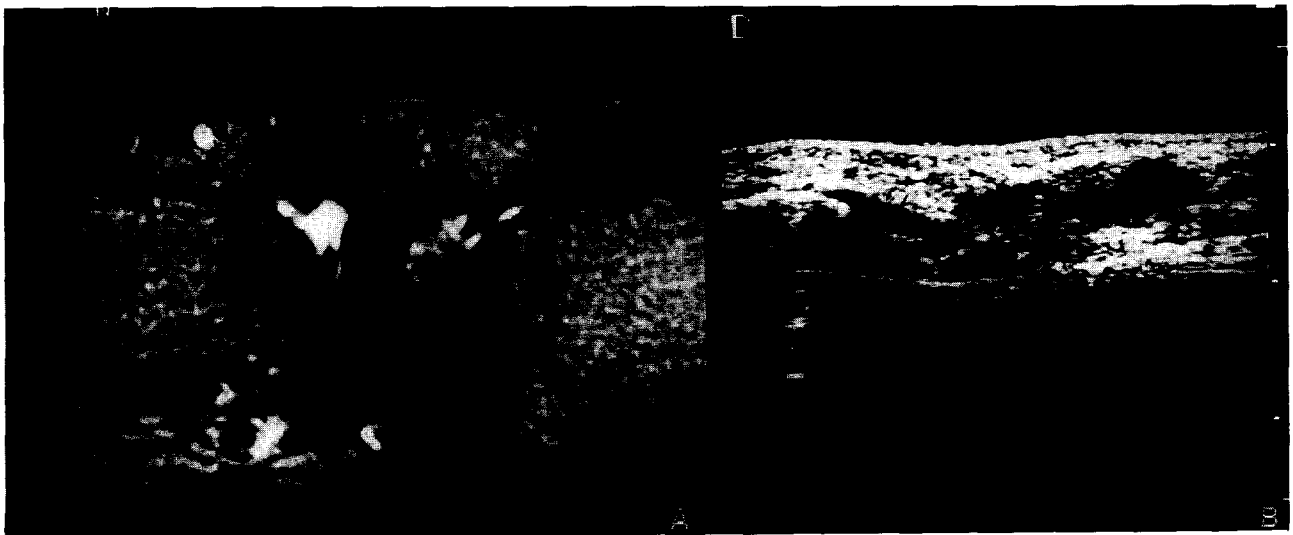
Calcaneofibular ligament: (A) Oblique coronal proton weighted MR image shows calcaneofibular ligament beneath the peroneal tendon (arrows) (B) Ultrasonography shows calcaneofibular ligament as a lower echoic band.(arrows)
